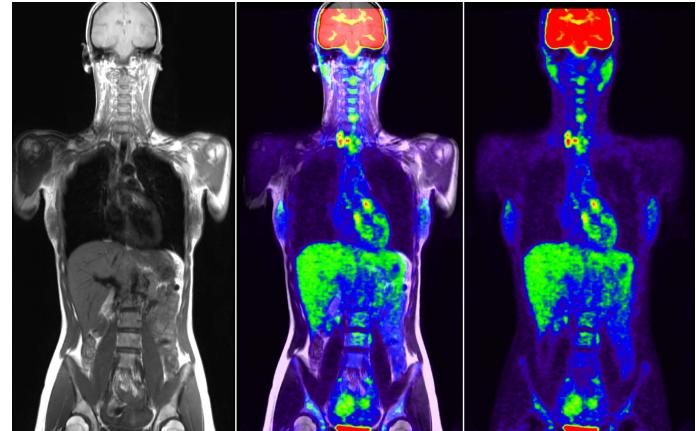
Hybrid whole-body PET/MRI dataset. T1 TSE (left), ¹⁸F-FDG PET (right), fused PET/MRI dataset (center).
